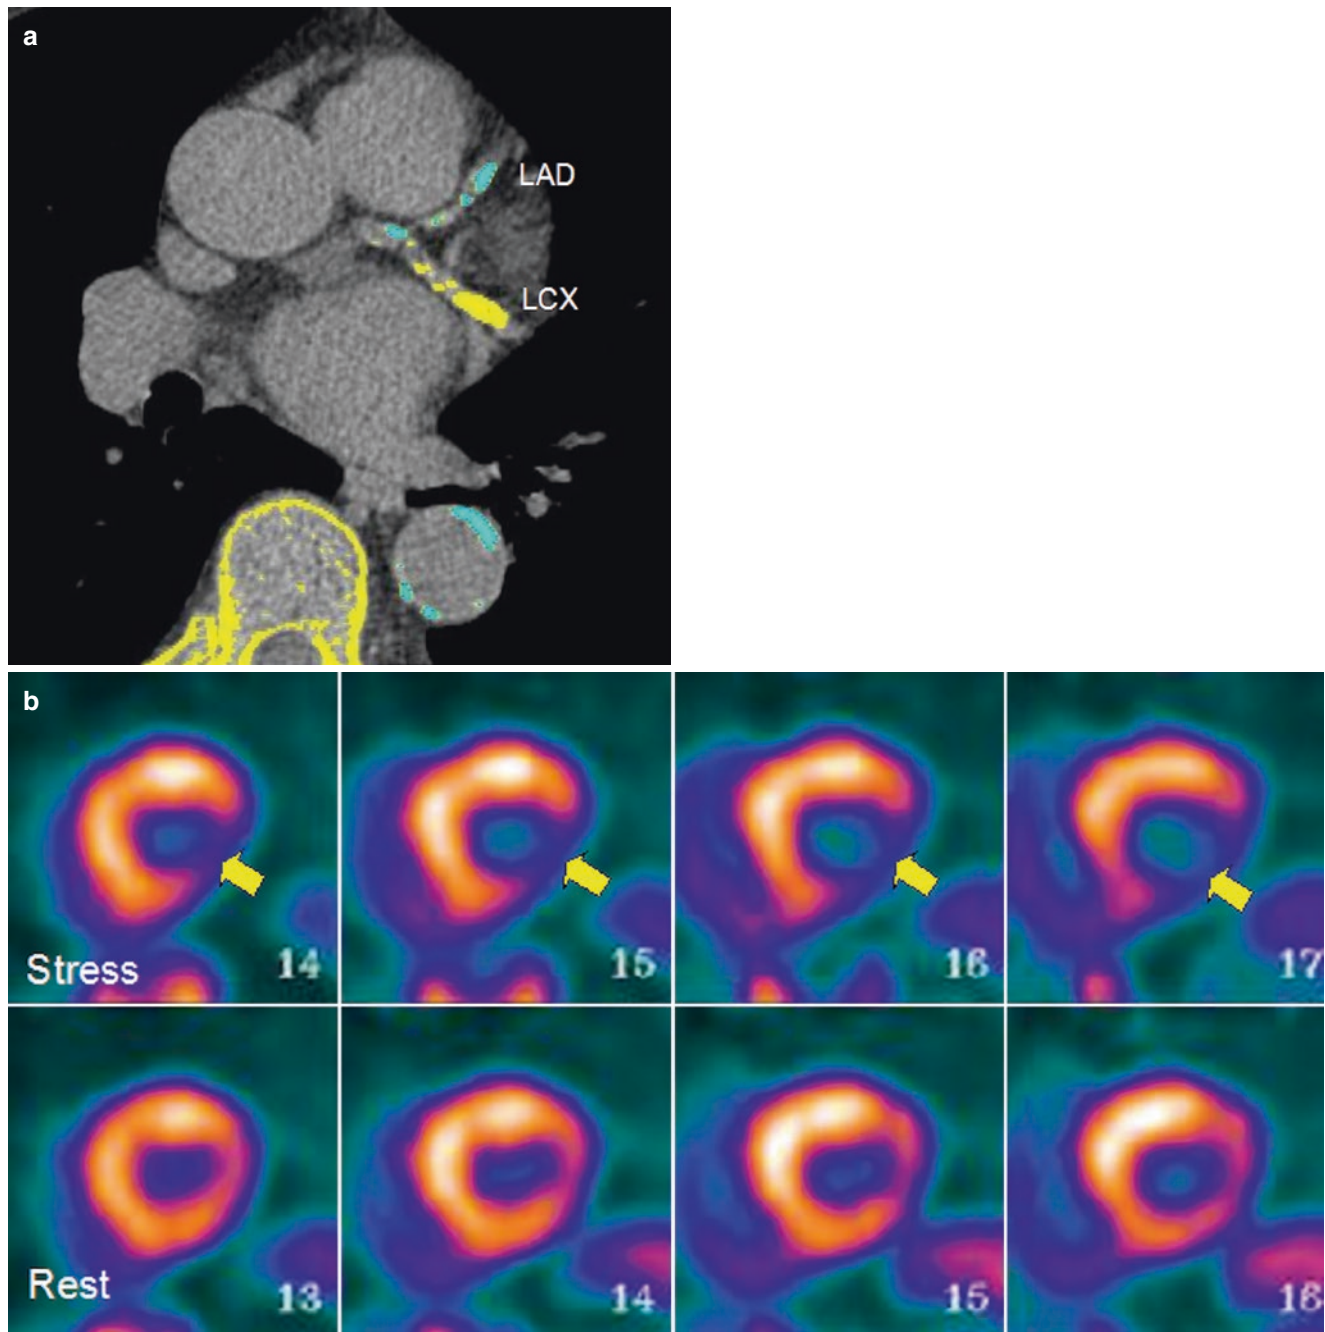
(a) Axial chest CT image showing dense calcification of the left anterior descending coronary artery (LAD) and left circumflex coronary artery (LCX). (b) Corresponding stress and rest short axis myocardial perfusion images showing an inferolateral perfusion defect
